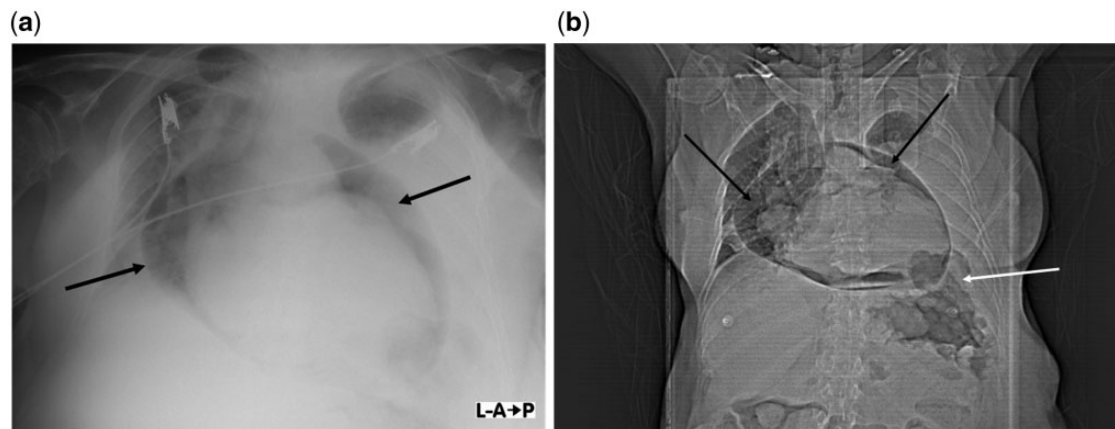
(a) Plain chest X-ray [anterior–posterior (AP) view, supine position] revealing air around the heart (black arrows). (b) Computed tomography scout radiograph of the thorax and upper abdomen (AP view, supine position) depicting a large pneumopericardium (black arrows) and suspected colo-pericardial fistula (white arrow).
